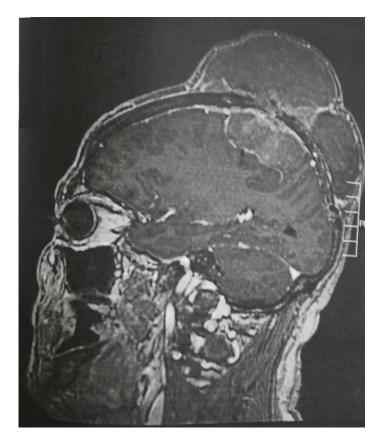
Pre-operative MRI of a 62-year-old male with an anaplastic meningioma with a large extracranial component. At the time of his presentation, he said he had "two cysts" in his head since two years ago and that he had not yet had the opportunity to have them removed. He had also been feeling intense headaches since that time.
